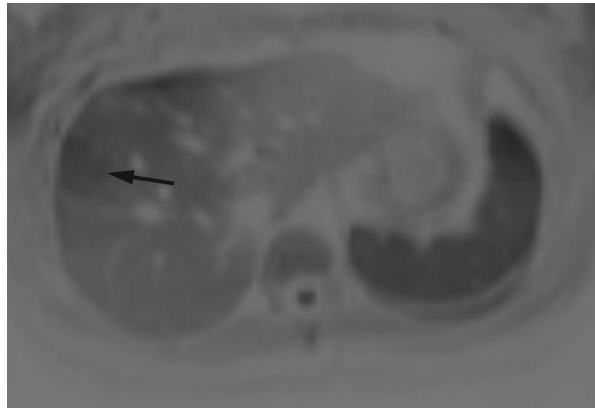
FNH. Annotated. Liver. MRI. DWI (inverted grayscale). b=500. Axial plane. An arrow points to the liver mass in the right lobe. Intensity of the mass is similar to that of the background liver.
